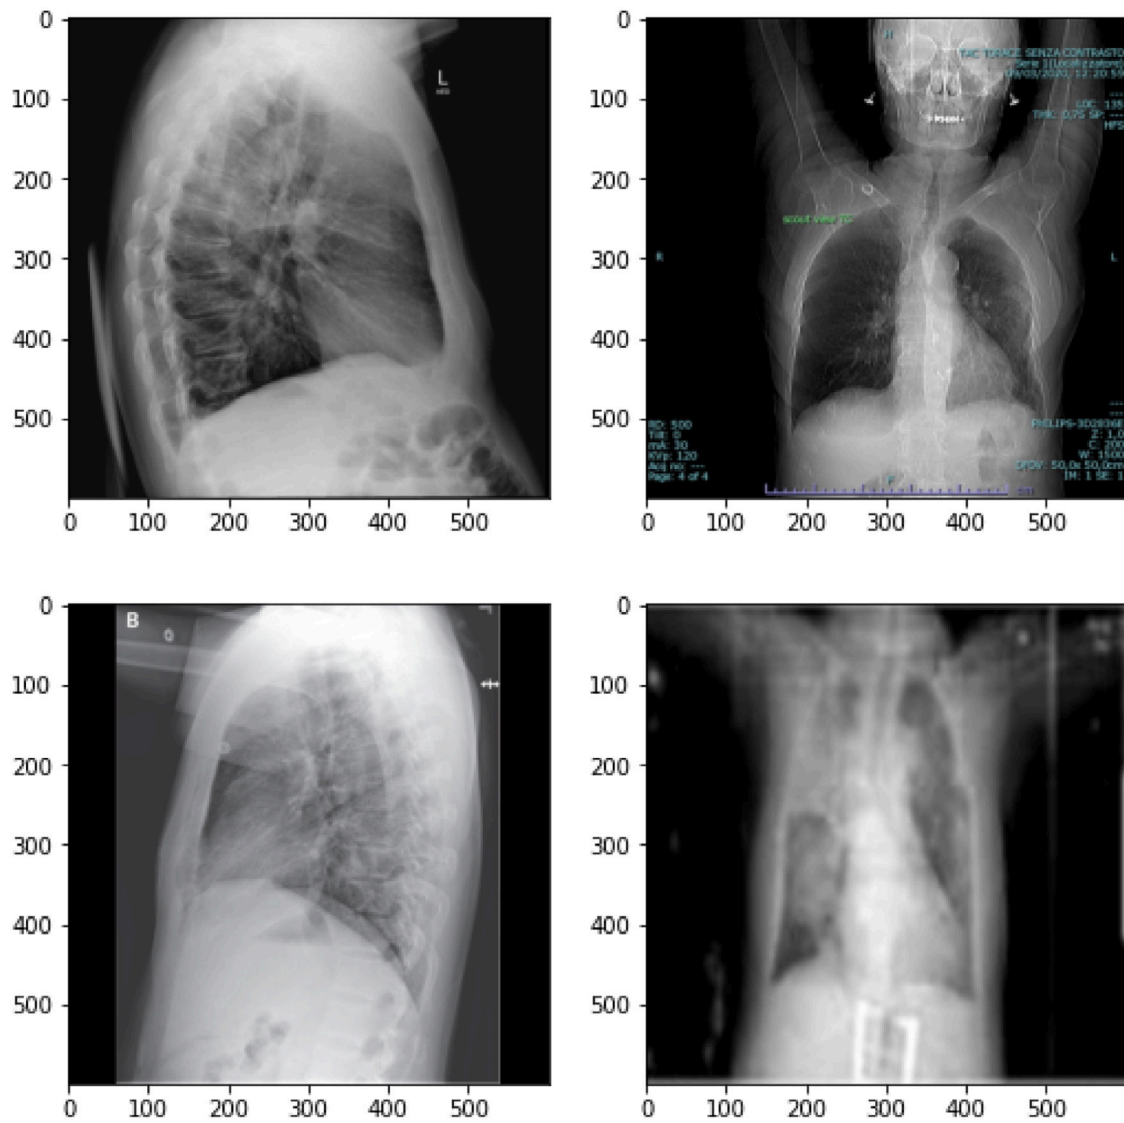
Misaligned thoracic X-ray images from collected dataset.
